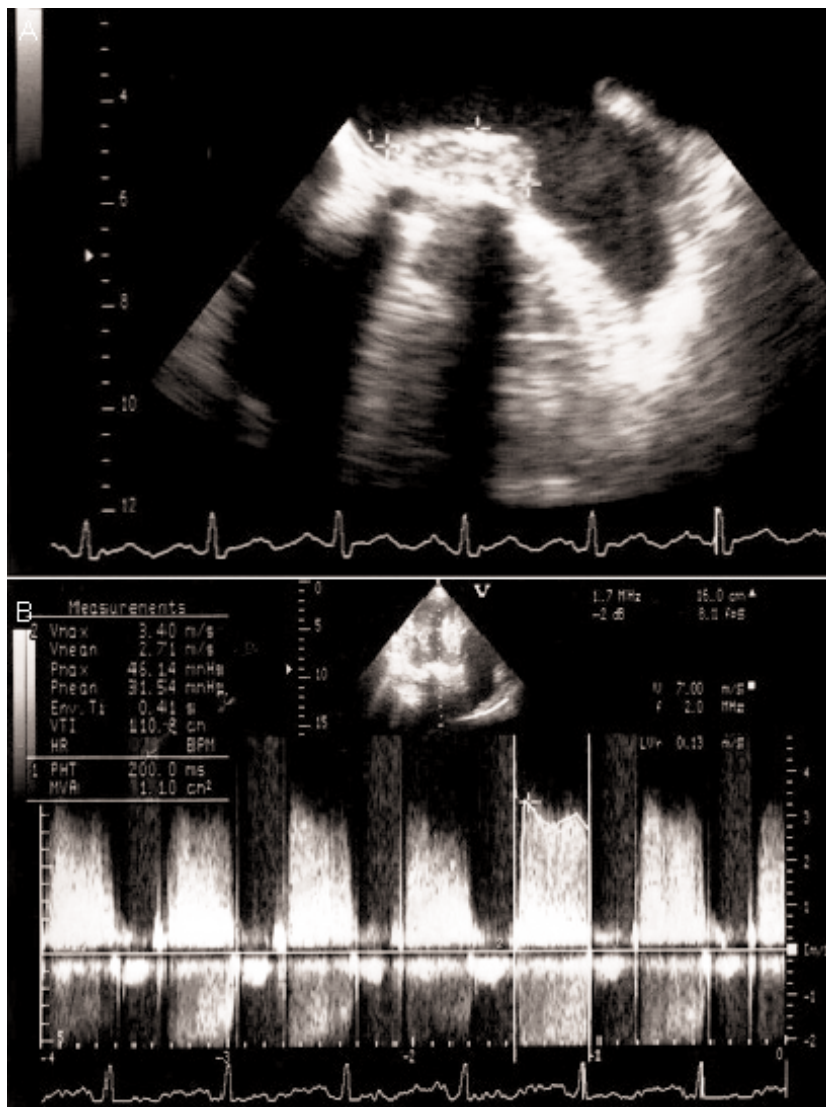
Transesophageal echocardiography revealed prosthetic valve thrombus and elevated mean mitral valve pressure gradient.
